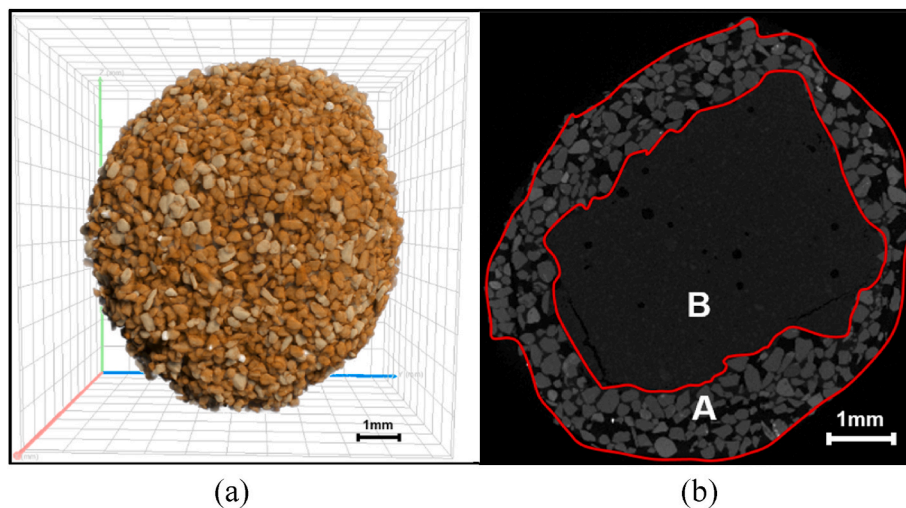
Nano-CT images of the CC-C type capsule. (a): The 3D image of the capsule; (b): The 2D image of the internal structure of the capsule (A: wall material; B: Core material).
